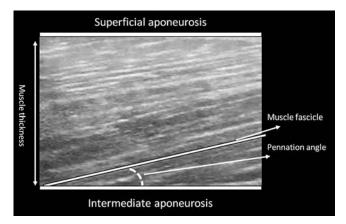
A two-dimensional ultrasound image of the BFlh. The image was along the longitudinal axis of the posterior thigh. From these images, it is possible to determine the superficial and intermediate aponeuroses, muscle thickness, and angle of the fascicle in relation to the aponeurosis. Estimates of fascicle length can then be made via trigonometry using an equation validated against cadaveric tissue (5).
